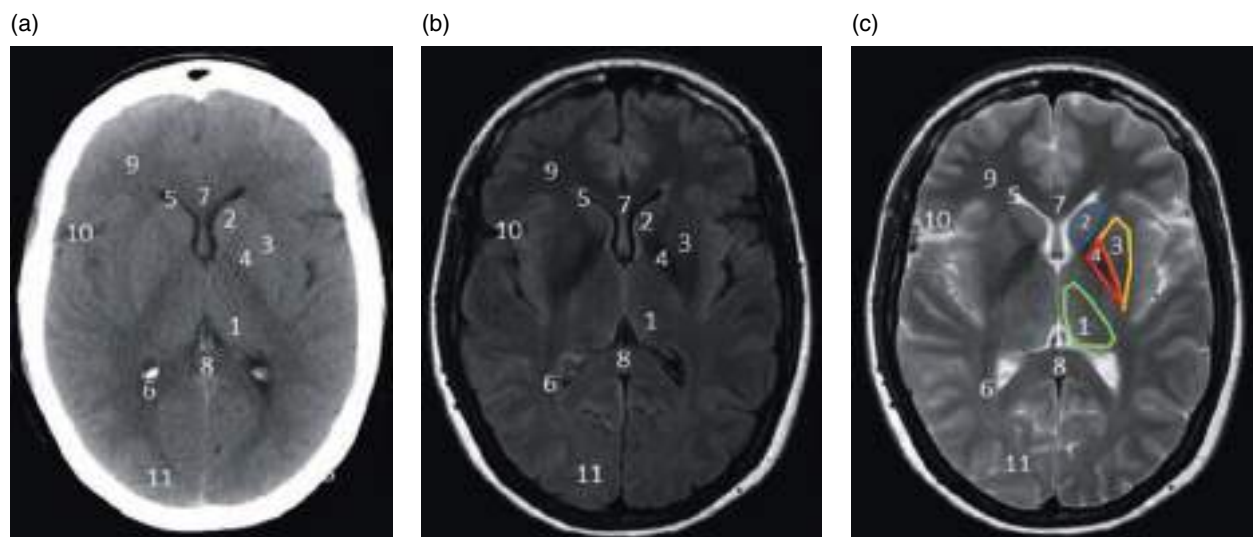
Supratentorial axial anatomy, section at the level of the base ganglia. (a) Axial noncontrast CT image. (b) Axial FLAIR T2-weighted MRI. (c) Axial TSE T2-weighted MRI. 1, thalamus; 2, caudate; 3, putamen; 4, globus pallidus; 5, frontal horn of the lateral ventricle; 6, occipital horn of the lateral ventricle; 7, genu of the corpus callosum; 8, splenium of the corpus callosum; 9, frontal lobe; 10, Sylvian fissure; 11, occipital lobe.
